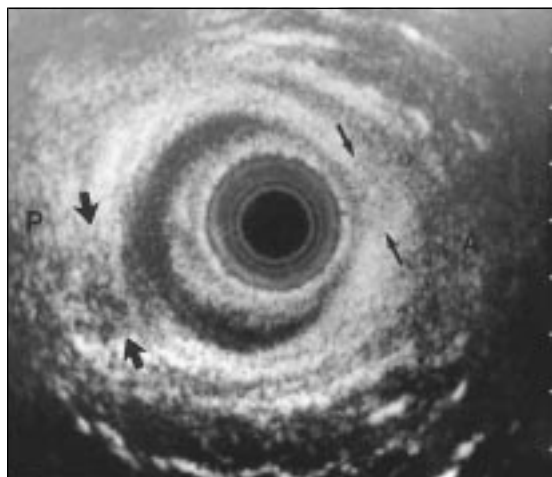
Ultrasound scan showing the anal canal of a 50 year old woman with passive faecal soiling. There is anterior (A, thin arrows) damage to the internal and external sphincter muscles related to childbirth and posterior (P, thick arrows) damage to the internal and external sphincter muscles related to haemorrhoidectomy
